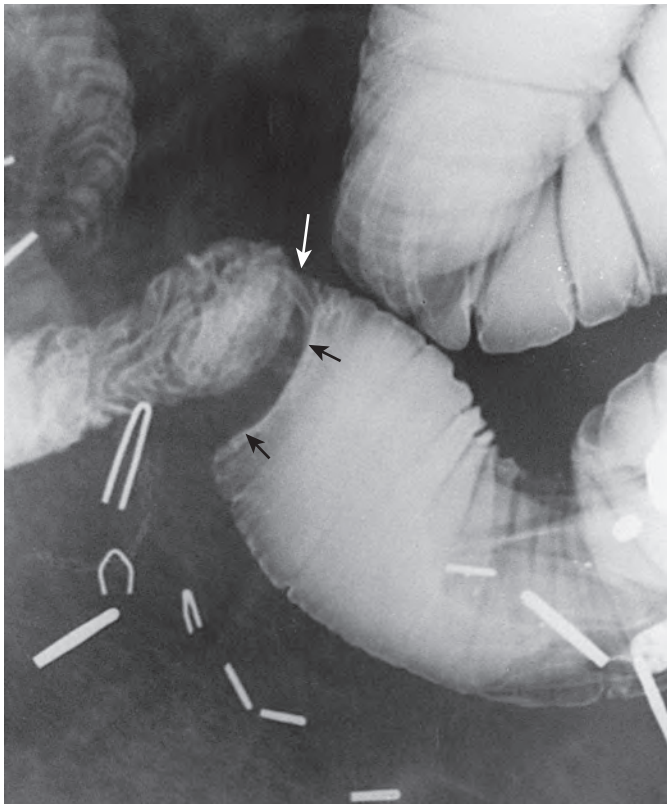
Partial small bowel obstruction by an adhesive band. Spot radiograph from an enteroclysis shows a long linear lucency (black arrows), which represents an adhesive band crossing the ileum. The ileum is focally narrowed (white arrow) by the band. Note preservation of small bowel folds (white arrow) in the area of narrowing and dilation of the bowel proximal to the band with collapse of bowel distal to the band.
